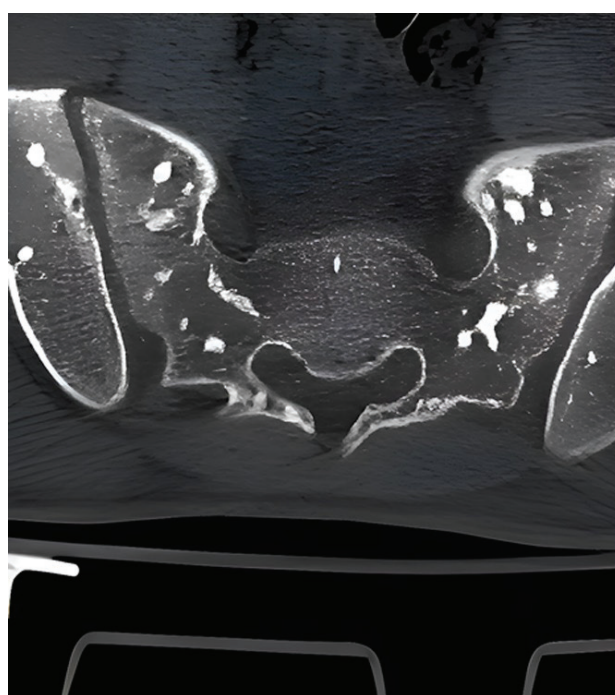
The CT of the pelvis showing hyperostotic areas.
